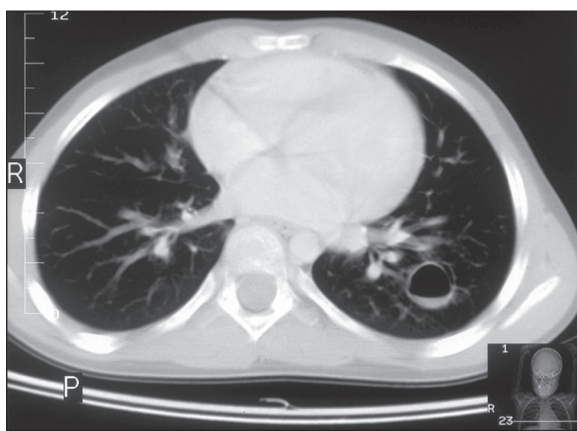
Axial CT scan of the chest, pulmonary window. Abscess of staphylococcal etiology in the lower lobe of the left lung.
